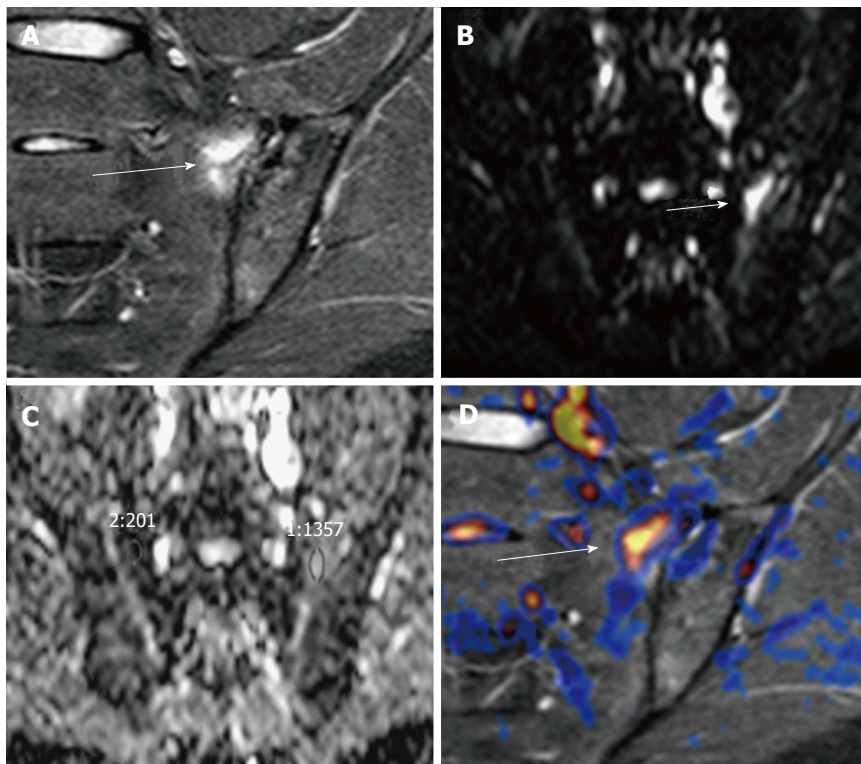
Acute sacroiliitis in a 32-year-old woman with left hip pain. A-C: Coronal STIR shows a focus of subchondral bone edema in the left hemisacrum (arrow, A), which appears hyperintense on (B) high b value DWI, with (C) significantly higher ADC values than contralateral bone marrow ($1.3 \times 10^{-3} \text{ mm}^2/\text{s}$ vs $0.2 \times 10^{-3} \text{ mm}^2/\text{s}$); D: Fused DWI and STIR images allow a better depiction of bone edema. STIR: Short inversion time recovery; DWI: Diffusion-weighted imaging; ADC: Apparent diffusion coefficient.
